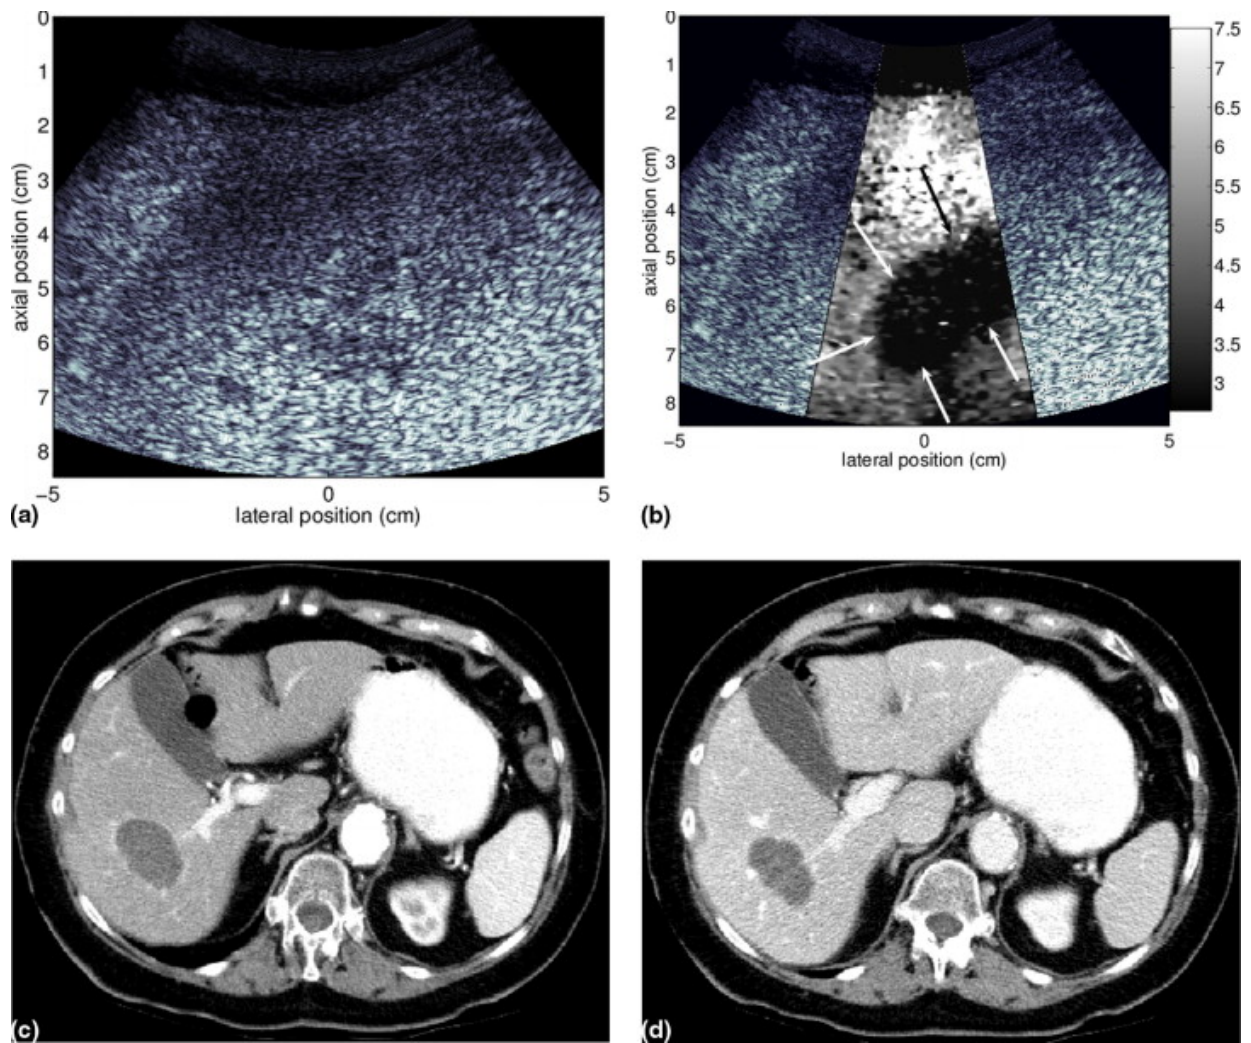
A thermal lesion resulting from radiofrequency ablation of a metastatic liver mass, imaged with B-mode (a) and ARFI (b), with verification of the tumor borders in postoperative CT (c&d). Reprinted from [44], with permission from Elsevier.
